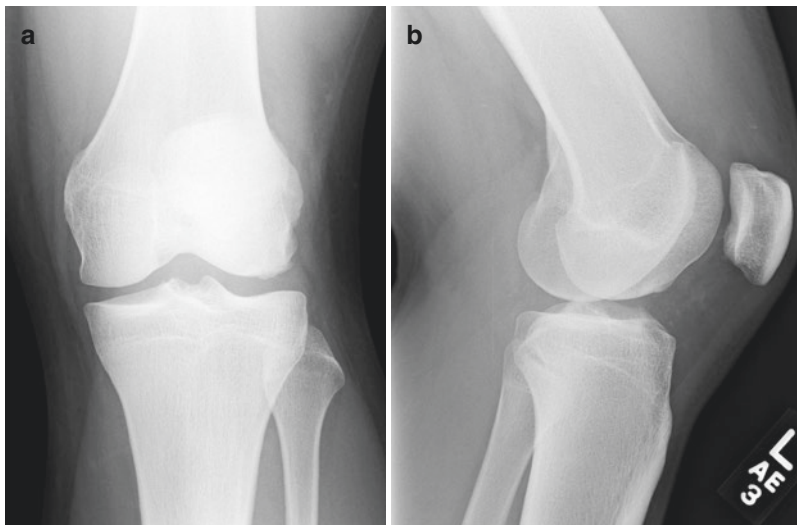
An 18-year-old man who presented with left knee pain after a collision with another player during a football match. (a) Frontal and (b) lateral radiographs of the left knee show no fracture or dislocation. (c) Skyline view of the knee, however, shows a bony fragment at the medial aspect of the patella (*arrow*), suggestive of an avulsion fracture. (d) Axial
